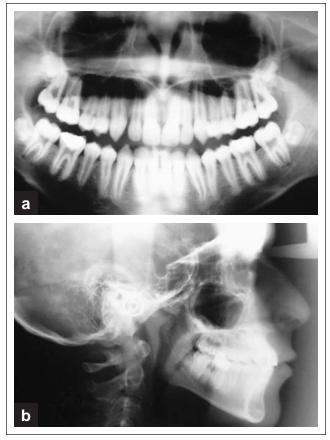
Radiographic views after orthodontic treatment: a. Panoramic view; b. Lateral cephalometric radiography view.
